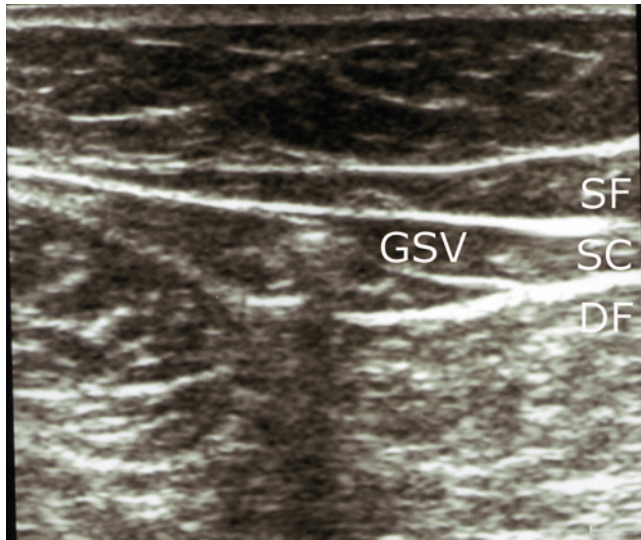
Foam functions as an efficient ultrasound contrast medium because of its air content. Its injection can be easily monitored. Its US appearance is that of a solid hyperechogenic core with an acoustic shadow projected on the tissue below.
